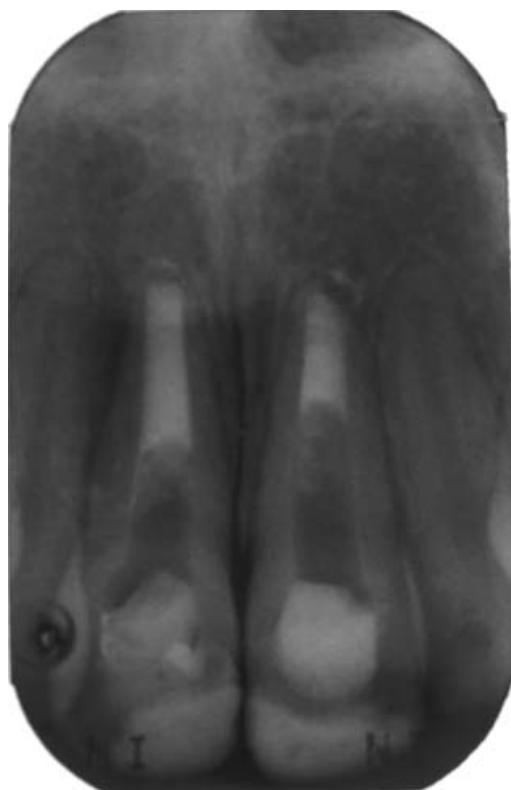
shows the radiographic appearance of an MTA apical barrier in the non-vital immature maxillary incisors of a 13 years old.
